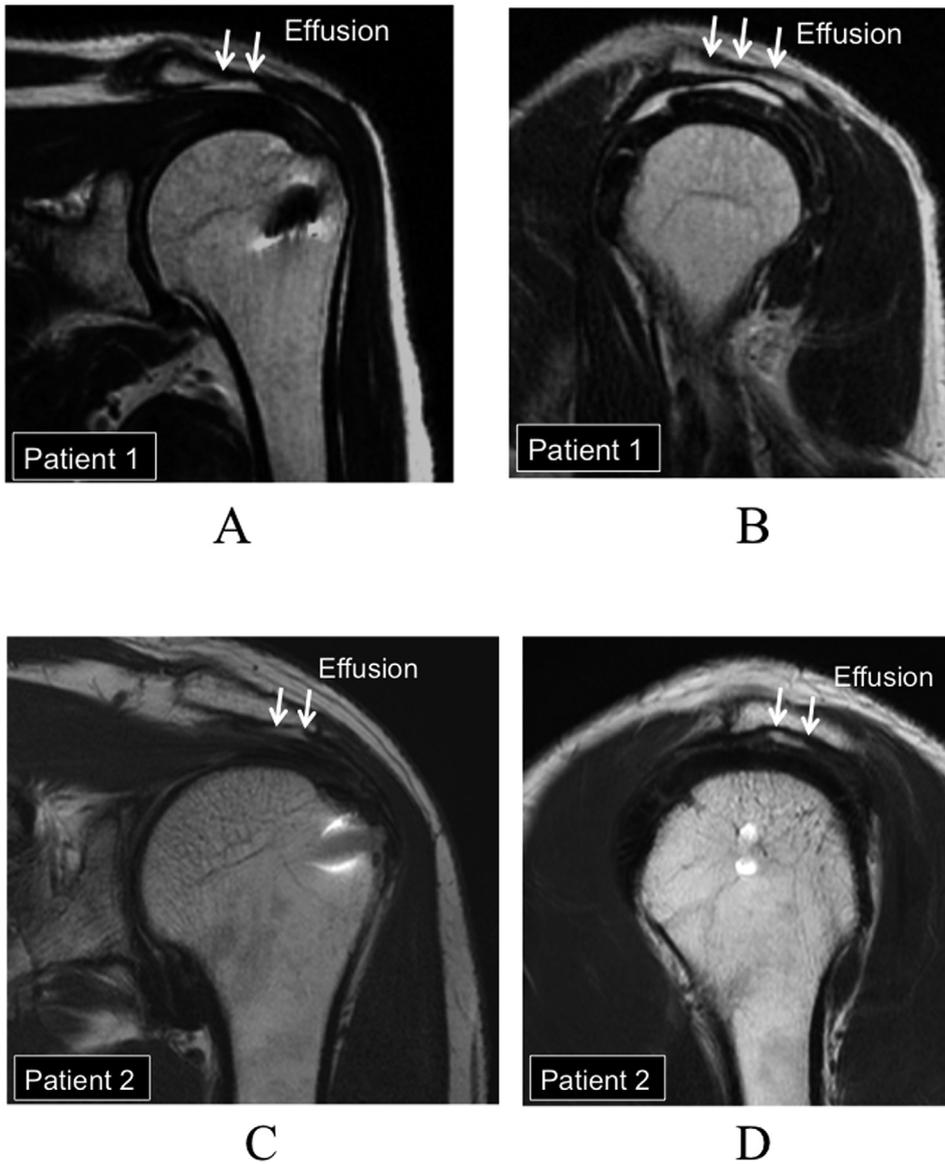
Coronal T2-weighted MRI 4 years after rotator-cuff repair in patient 1 (a: coronal image, b: sagittal image) and 18 months after rotator cuff repair in patient 2 (c: coronal image, d: sagittal image). White arrows indicate subacromial effusion. The repaired tendon has healed in both patients.
